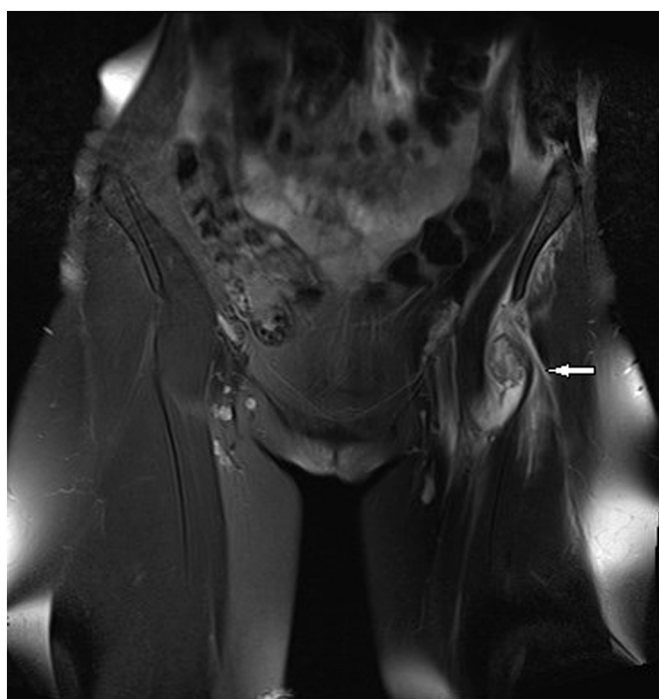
On MRI, a sharply delineated lesion with inhomogeneous high signal intensity with peripheral low signal intensity was observed (Fig. 2).
